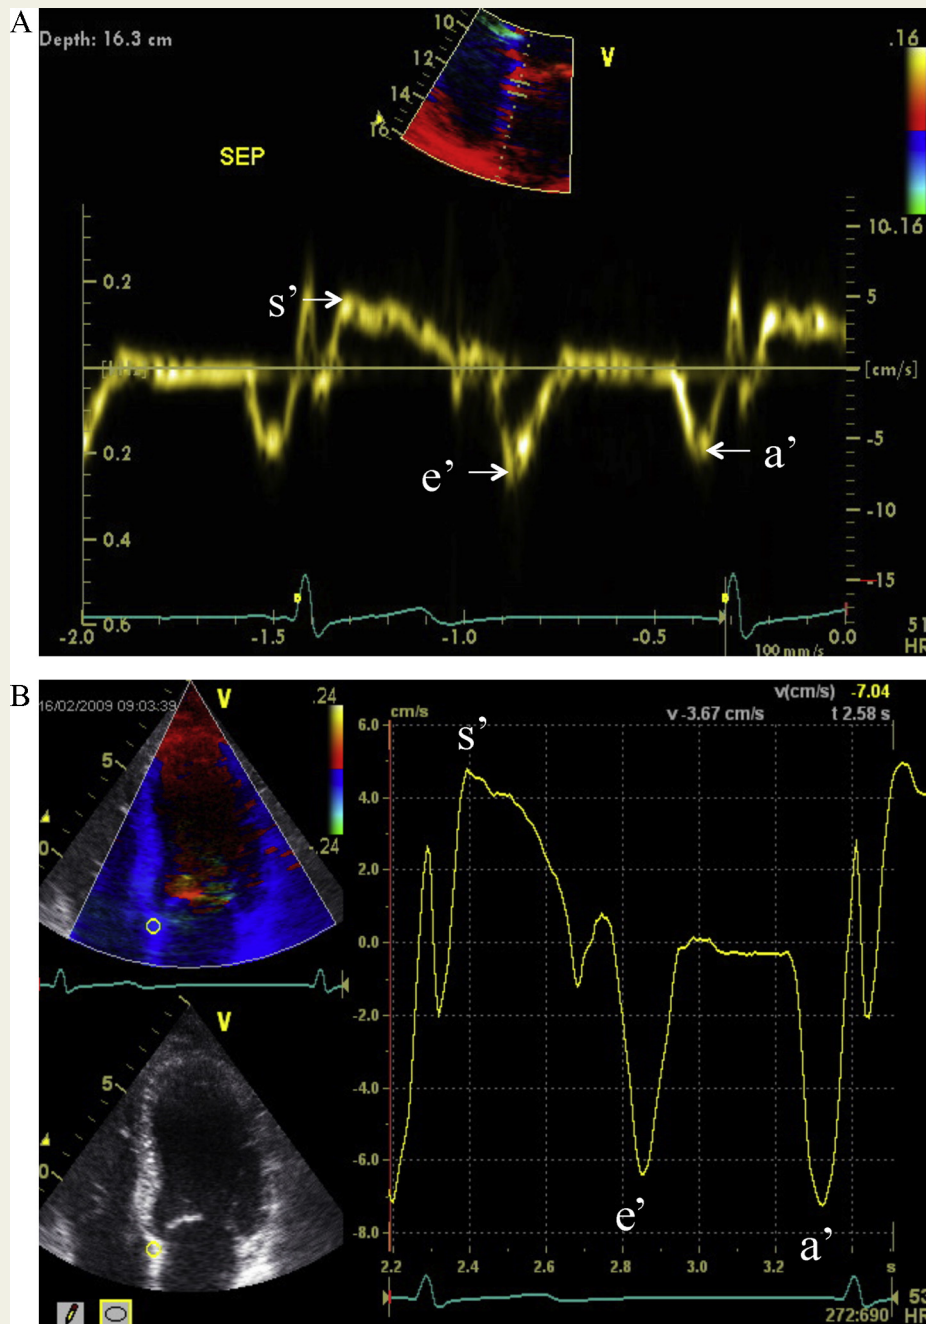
(A) Pulsed wave tissue Doppler Imaging from the apical 4 chamber view sampling from the septal mitral annulus (B) Colour Tissue Doppler Imaging from the apical 4 chamber view sampling from the septal mitral annulus.
